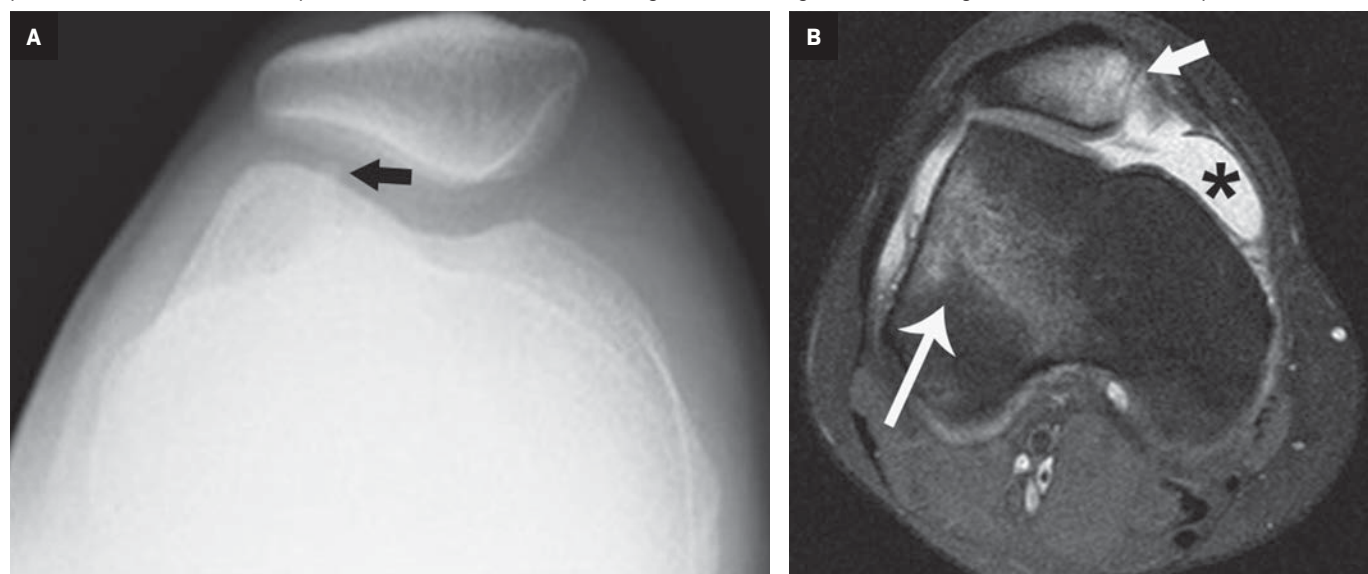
Transient patellar dislocation. (A) Sunrise radiograph of a patient with pain and instability shows a small ossific fragment (arrow) in the patellofemoral compartment. (B) Axial T2 fat saturated MR image shows the classic bone marrow contusion pattern centered at the medial patellar pole (short arrow) and lateral aspect of the lateral femoral condyle (long arrow), allowing for definitive diagnosis. An effusion is also present (asterisk).
